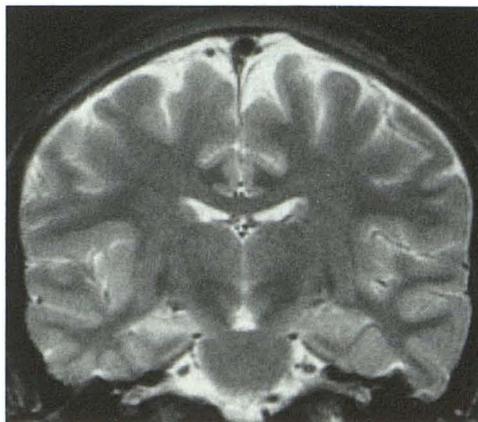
Case 2, 23-year-old man with right mesial temporal sclerosis. Spin-echo T2-weighted coronal image 2500/80. The right hippocampus is slightly smaller (mainly less vertical diameter) when compared with the left, and there is very high signal. This is the typical MR appearance of hippocampal sclerosis.
